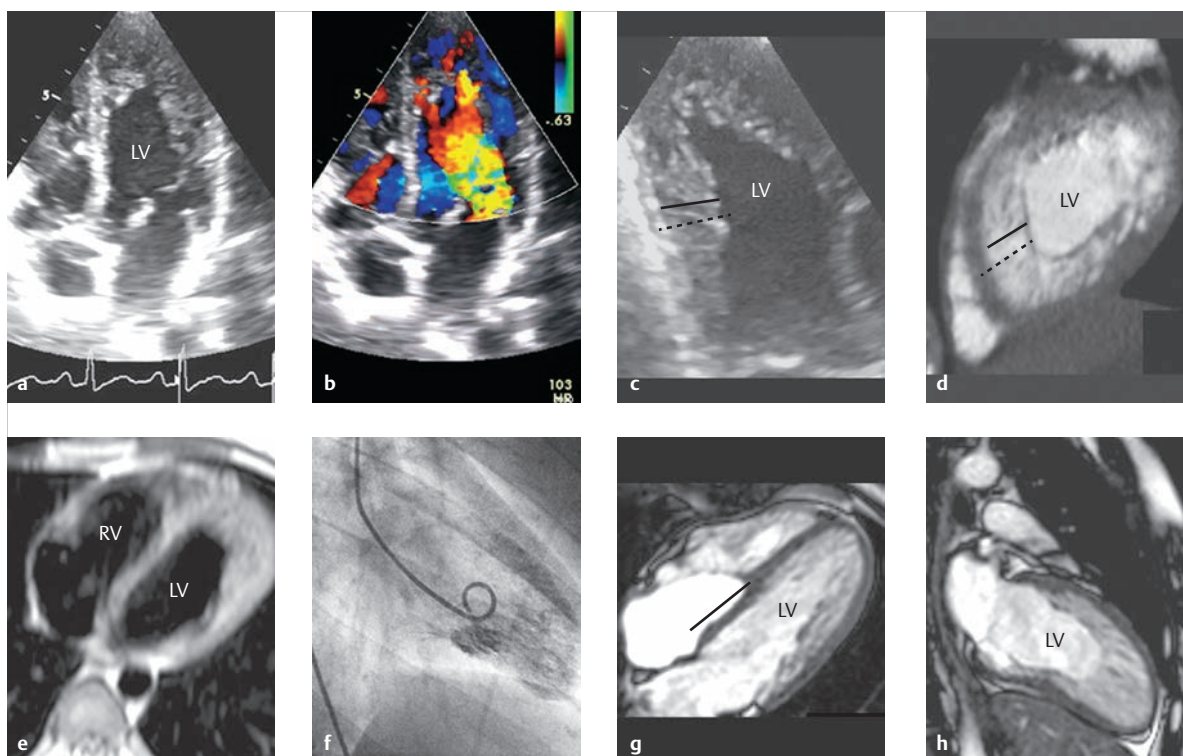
Noncompaction cardiomyopathy. Twenty-eight-year-old woman with noncompaction cardiomyopathy of the left and right ventricle and concurrent Ebstein's anomaly. The 2-D TTE, 4-chamber view (a, b) depicts the pronounced apical and lateral trabeculation and a more than 2:1 ratio of noncompacted to compacted myocardium. This is particularly visible in the magnification image of (c). Echocardiographic measurement is standardized based on systole. Unlike MRI, this procedure is able to differentiate between noncompacted and compacted segments. All other imaging procedures require measurement during end diastole in order to be able to clearly distinguish the blood-filled recesses (c, d, solid line) from compacted myocardium. The dotted line in c and d indicates overall myocardial thickness (compacted + noncompacted, trabeculated myocardium). Color Doppler (b) can also be used. Despite measurement during diastole, slow flow in the trabecula results in only limited differentiation between noncompacted and compacted myocardium in the T1w black blood sequence (e). The SSFP cine MRI, 4-chamber view, depicts the septal tricuspid leaflet displaced approximately 1.8 cm apically (g, line) with concurrent tricuspid valve insufficiency corresponding to the concurrent Ebstein's anomaly. The left ventricular ejection fraction was already slightly limited in MRI, measured at 49%. Midventricular MRI short-axis slices (i-l) depict almost complete "masking" of the noncompacted myocardium in the inversion recovery GE sequence after administering contrast agent (i) for late enhancement due to the contrast agent in the left ventricular cavum and recesses. The "masking" of the noncompacted myocardium also occurs due to the slow flow between the trabecula in the T2w STIR black blood sequence (j) and due to contraction during systole (l). The noncompacted myocardium is clearly visible during end diastole (k).
